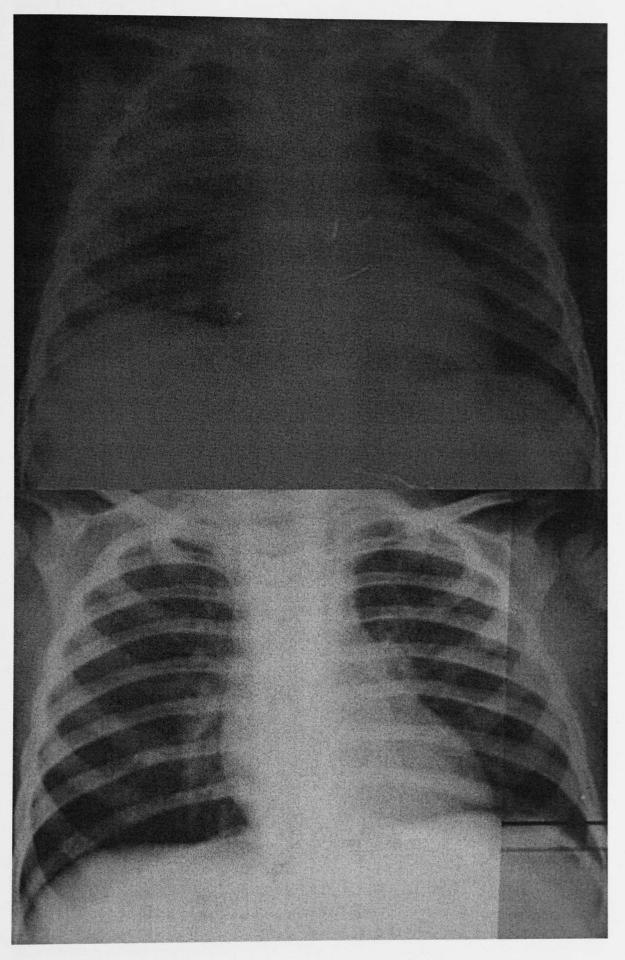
Chest x-rays from study children, where one of the two readers disagreed to diagnose them as pneumonia, and were confirmed as pneumonia after 3rd reader's opinion
